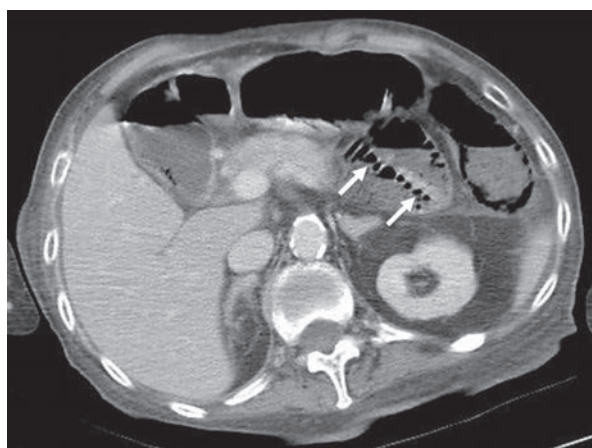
The follow-up abdominal computed tomography revealed pneumatosis intestinalis at colon, compatible with ischemic colitis (white arrows).
